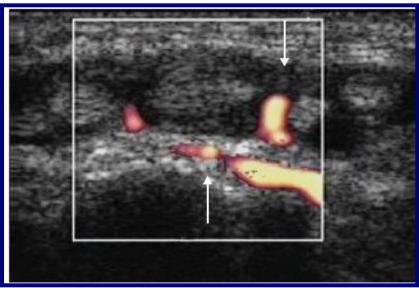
Transverse image at dorsal wrist showing hypoechoic synovial thickening (upper white arrow) surrounding extensor digitorum tendons (compartment IV) with increased vascularity on power Doppler (lower arrow). (6)
